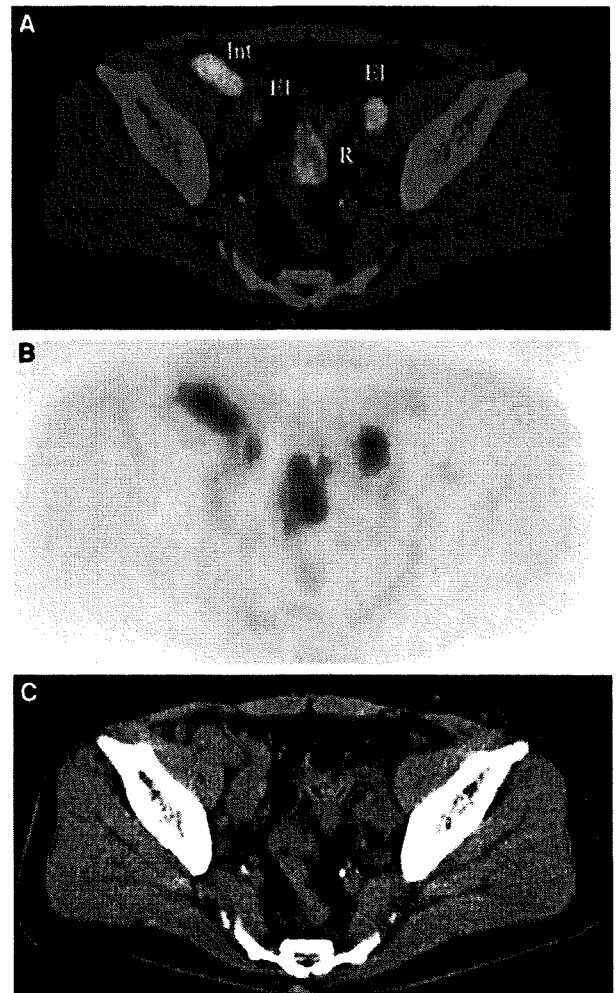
Axial noncontrasted PET/CT image (A), PET (B), and CT (C) shows multiple enlarged nodes with increased uptake in patient with follicular lymphoma. Focal uptake of intestine (Int) mimics abnormal uptake of external iliac lateral lymph node. El, external iliac lymph node and R, rectum.
